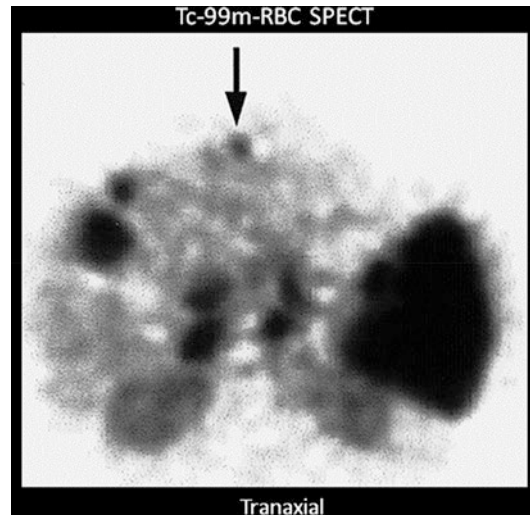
Selected image of Tc-99m-RBC SPECT images of the liver reveal multiple hemangiomas. The smallest one (*arrow*) was 0.7 cm
